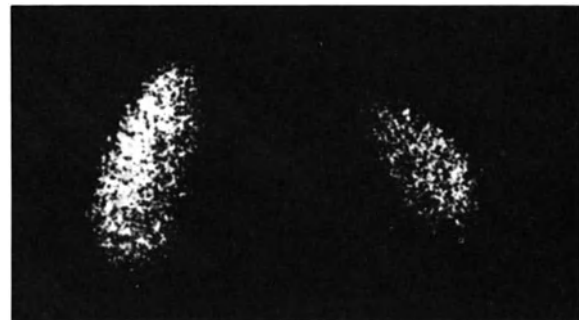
Static renal scintigram in right-sided pyelonephritis.
